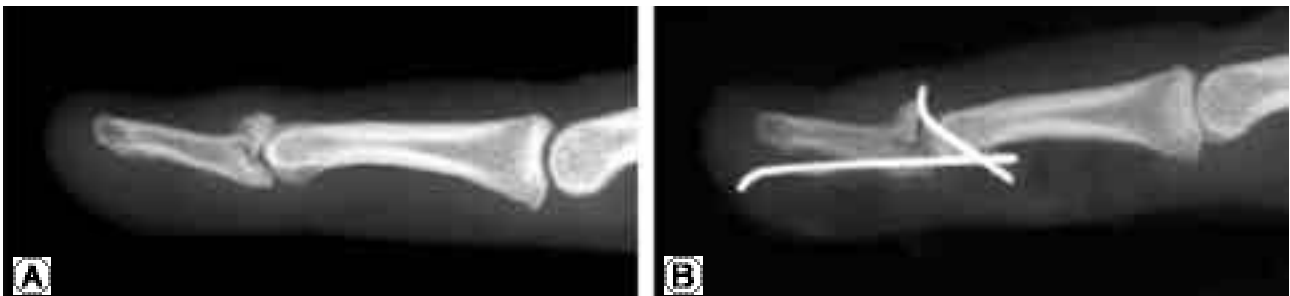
A 37 year old male patient had bony mallet finger injury on right ring finger for 3 weeks. (A) The initial x-ray showed a displaced dorsal fragment and articular involvement about 50% without subluxation. (B) Despite of blocking K-wire, the fractured fragment was displaced dorsally. Improper bending of the tip of K-wire make further displacement. The patient had developed extension lag 14 degrees.
